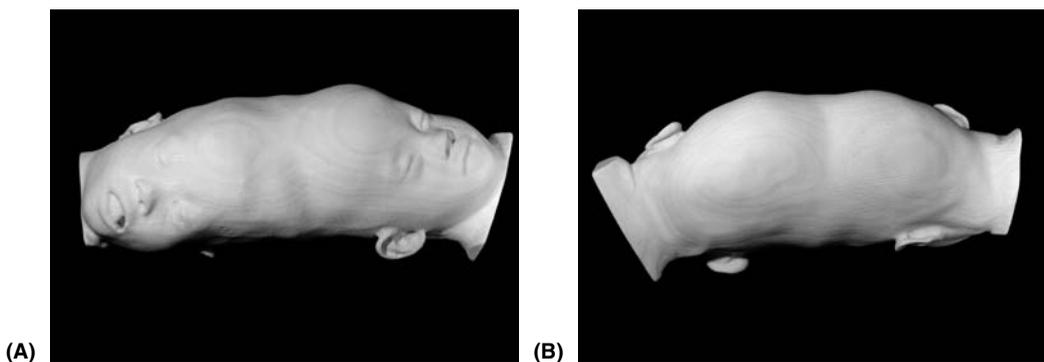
Three-dimensional model fabricated from computed tomography data. (A) Anterior view; twin A on left. (B) Posterior view; twin A on right. *Source:* From Montefiore Medical Center/Medical Modeling, LLC, Golden, Colorado, U.S.A.
